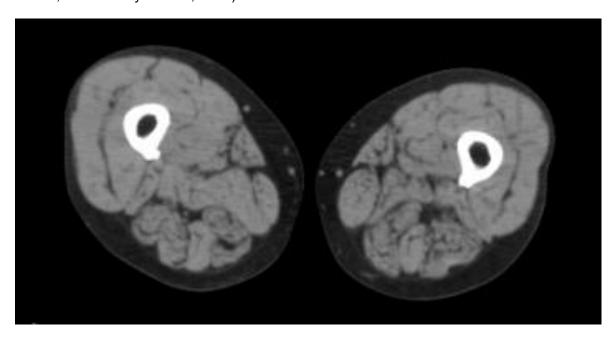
Mid-thigh CT scan. Male 72 years of age demonstrating adipose tissue (black), muscle (grey) and bone (white).
